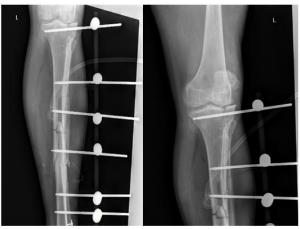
CT scan, X-rays - left leg external fixation
